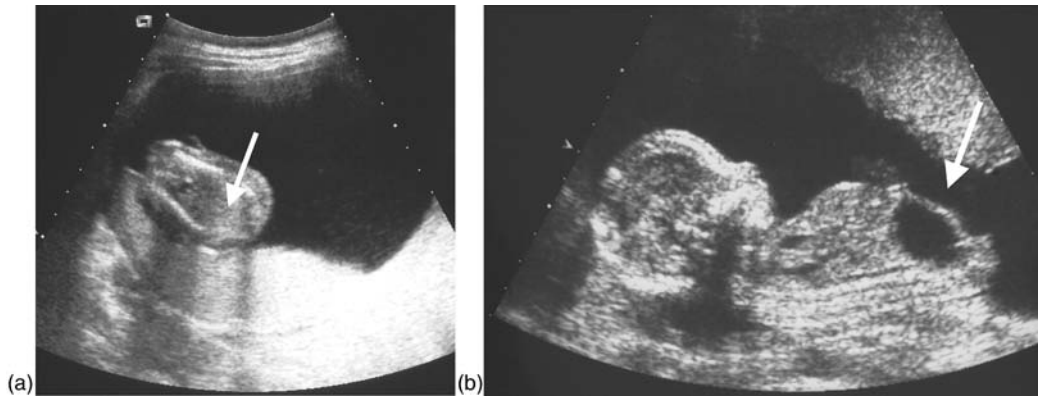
Ultrasound image of TTTS. (a) The donor is stuck to the uterine wall without bladder filling. (b) There is polyhydramnios in the sac of the recipient, who has a distended bladder.
